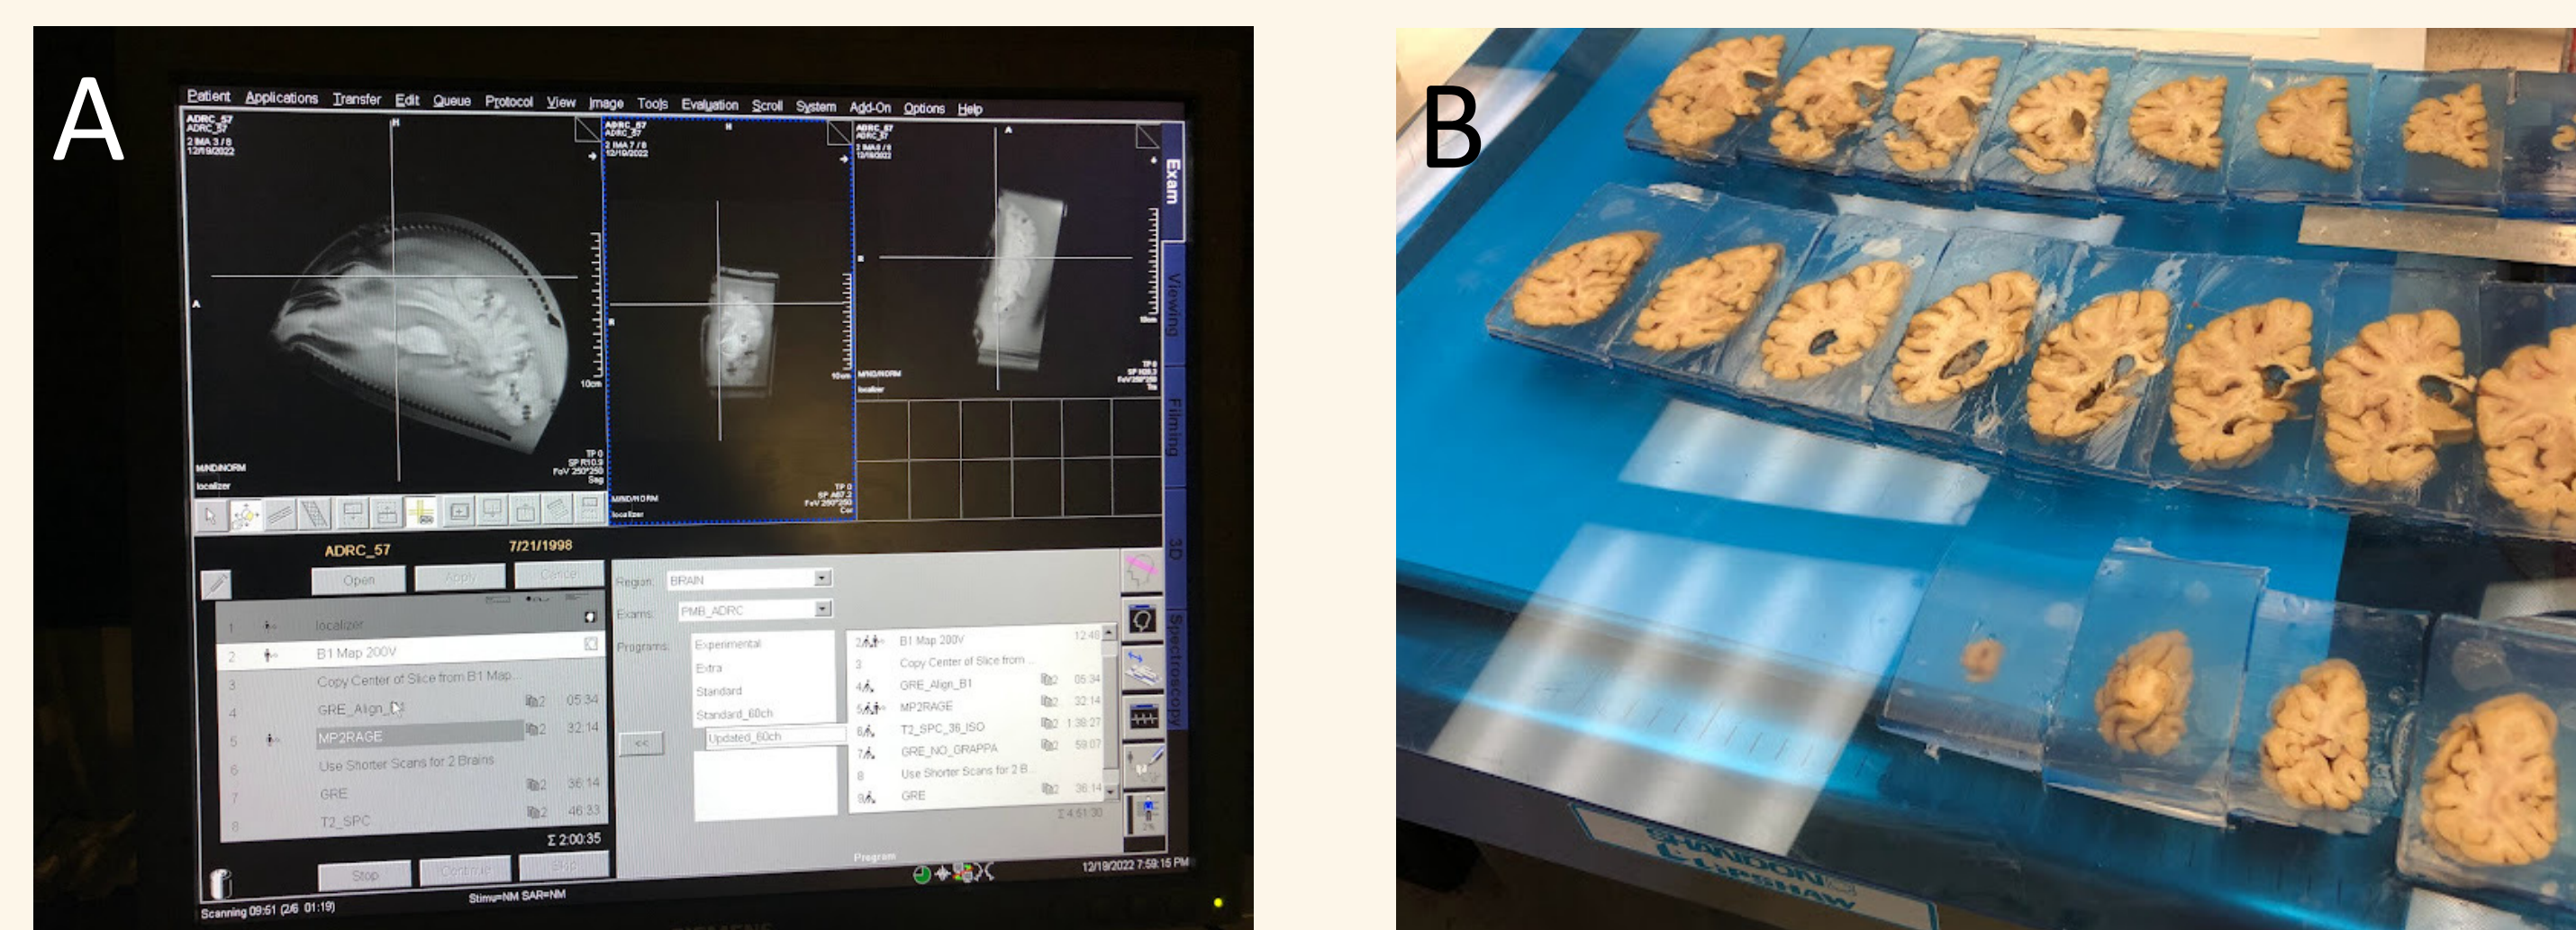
Postmortem Brain preparation. Brain is embedded in agar inside 3D printed container and is prepared for MRI scanning (A). Afterwards, brain is sectioned and aligned for tissue analysis (B).
